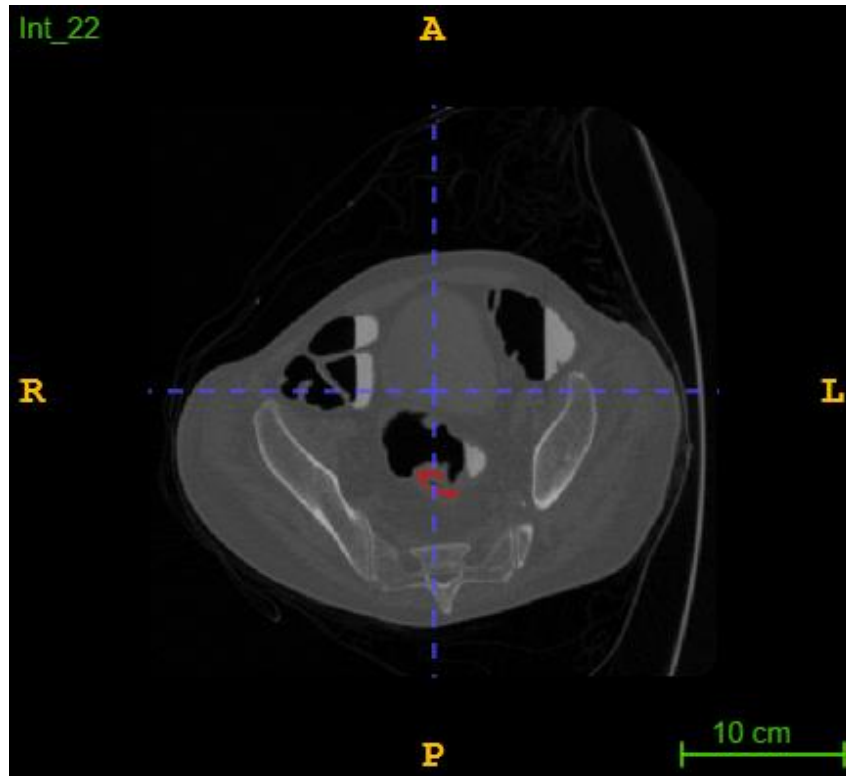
Slice extracted from a CT volume of a patient with colon cancer and his corresponding manual segmentation
